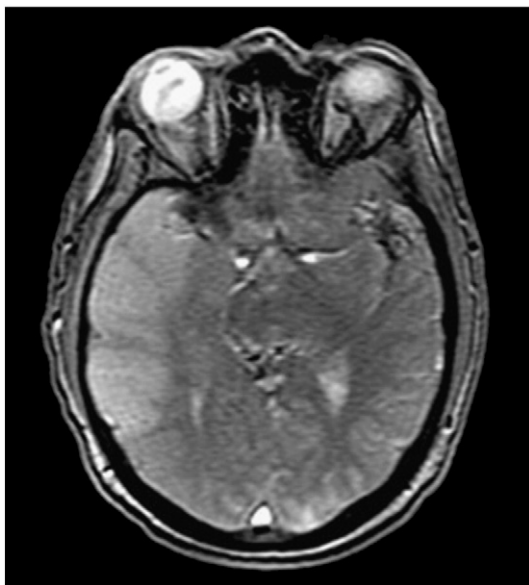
Brain MRI. Large right MCA territory ischemic stroke and degree of mass effect and 2–3 mm midline shift to the left.
